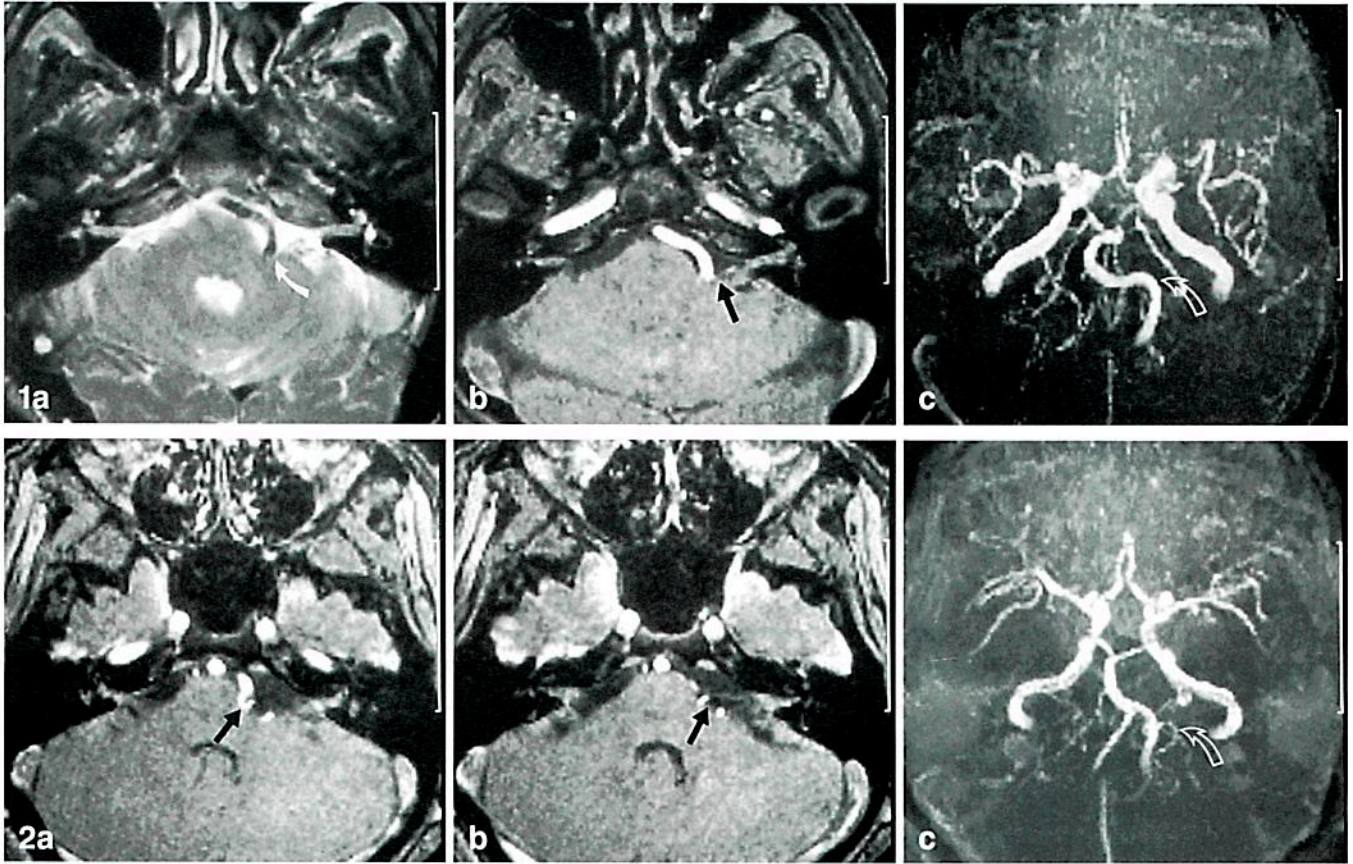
A 58-year-old patient, left hemifacial spasm (HS) for 4 years. a T2-weighted image shows the vertebral artery (VA) extending into the left cerebellopontine angle, compressing the brain stem and the facial nerve root exit zone (REZ) (arrow). b Representative 1.1 mm slice of the 3D-FISP acquisition at same level displays the VA with high signal intensity and better delineates the displaced facial nerve on the left (arrow). c Projectional magnetic resonance angiography (MAR), viewed 45° from below in an anteroposterior direction (calculated from the 3D-FISP 88 images in b) shows tortuous elongation of the VA and basilar artery (BA) with left and right convexity respectively. Note also non-visualization of the right VA
